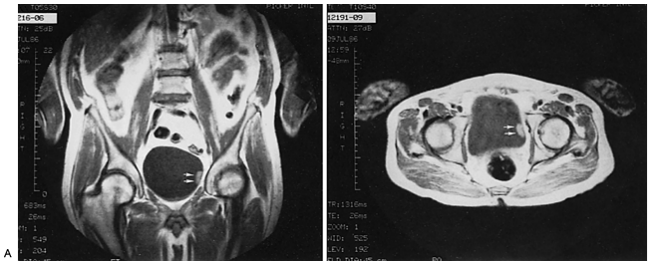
22. Superficial bladder cancer on T₁-weighted magnetic resonance imaging. The small tumor (*double arrows*) is seen in the coronal (A) and axial (B) planes. Note that the bladder wall is undisturbed and there is no evidence of transmurular invasion. No adenopathy is present. The natural contrast between the tumor and the urine in the bladder allows the tumor to be delineated.
